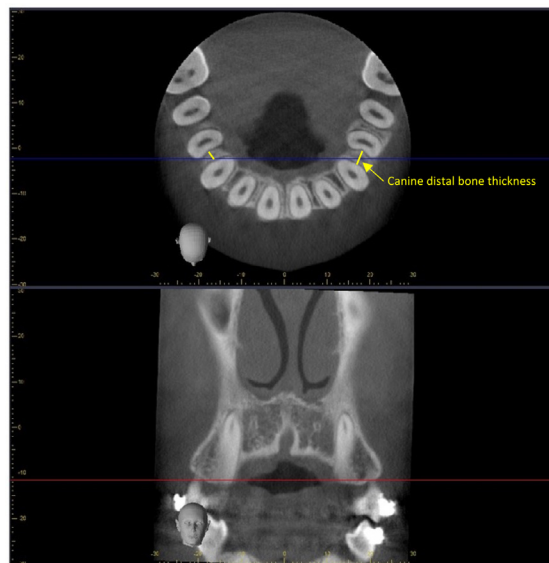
CBCT images for evaluation of distal interseptal bone thickness. Measurement was done on axial plane, at cemento enamel junction level.
